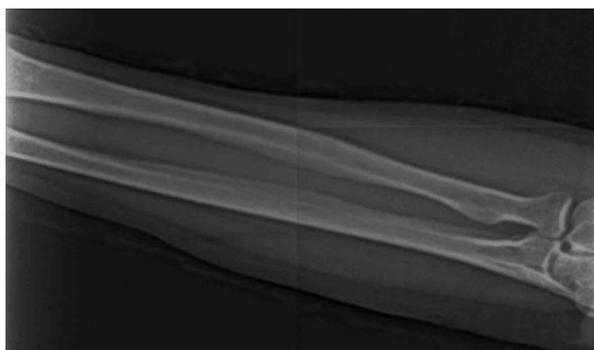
Fig V b- Radiograph showing barrowing of long bones
